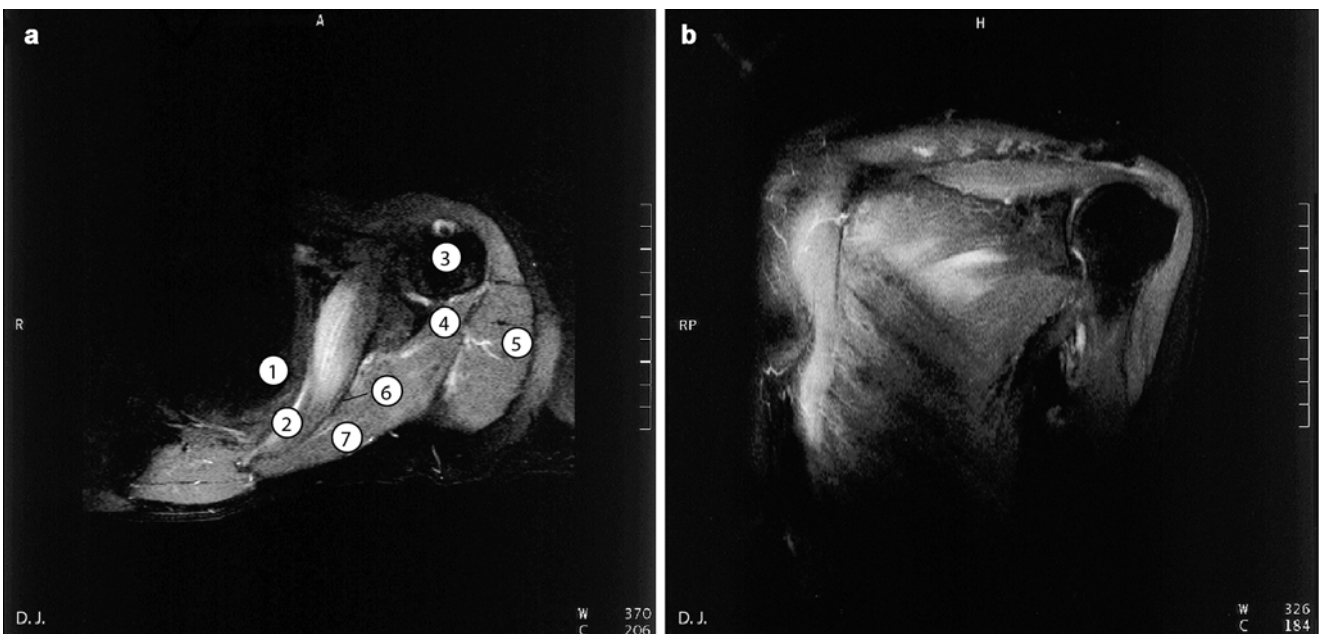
Magnetic resonance images 10 min after injection of 10 mL ropivacaine, without radiographic contrast medium, into the subscapular fossa. (a) Axial (cross section). (b) Paracoronal. (1) Thorax wall, (2)
